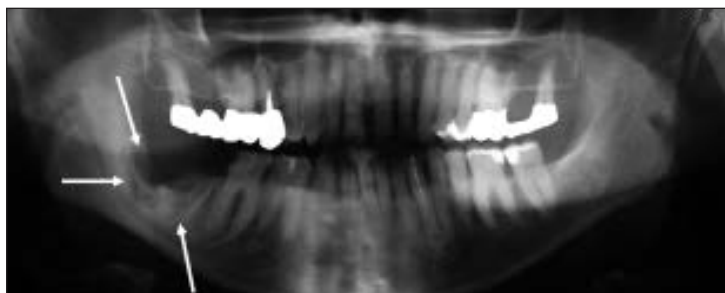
Panoramic radiography showing irregular radiolucency and osteolytic area in the right mandibular angle and region 47-48 because of BRONJ (white arrows) in Case 8.
